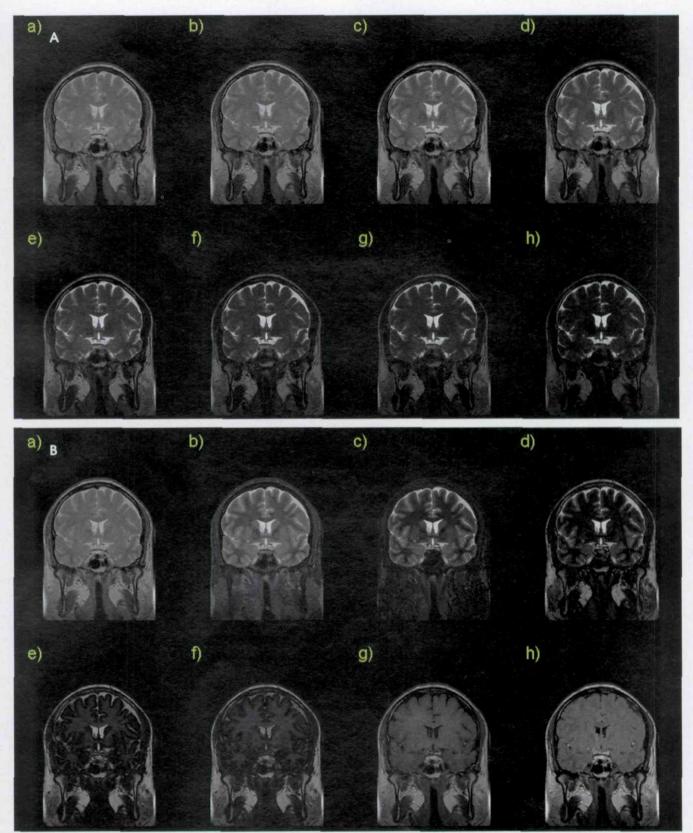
Magnetic resonance image synthesis in the brain. Images of user variable weighting may be synthesized at the time of image interpretation. (A) User-varied echo times (TE, in milliseconds) and constant long TR. a) TE = 0, b) TE = 10, c) TE = 15, d) TE = 30, e) TE = 60, f) TE = 90, g) TE = 120, h) TE = 200. (B) User-varied inversion times (TI, in milliseconds). a) TI = 0, b) TI = 150, c) TI = 300, d) TI = 450, e) TI = 600, f) TI = 750, g) TI = 1500, h) TI = 2500.
